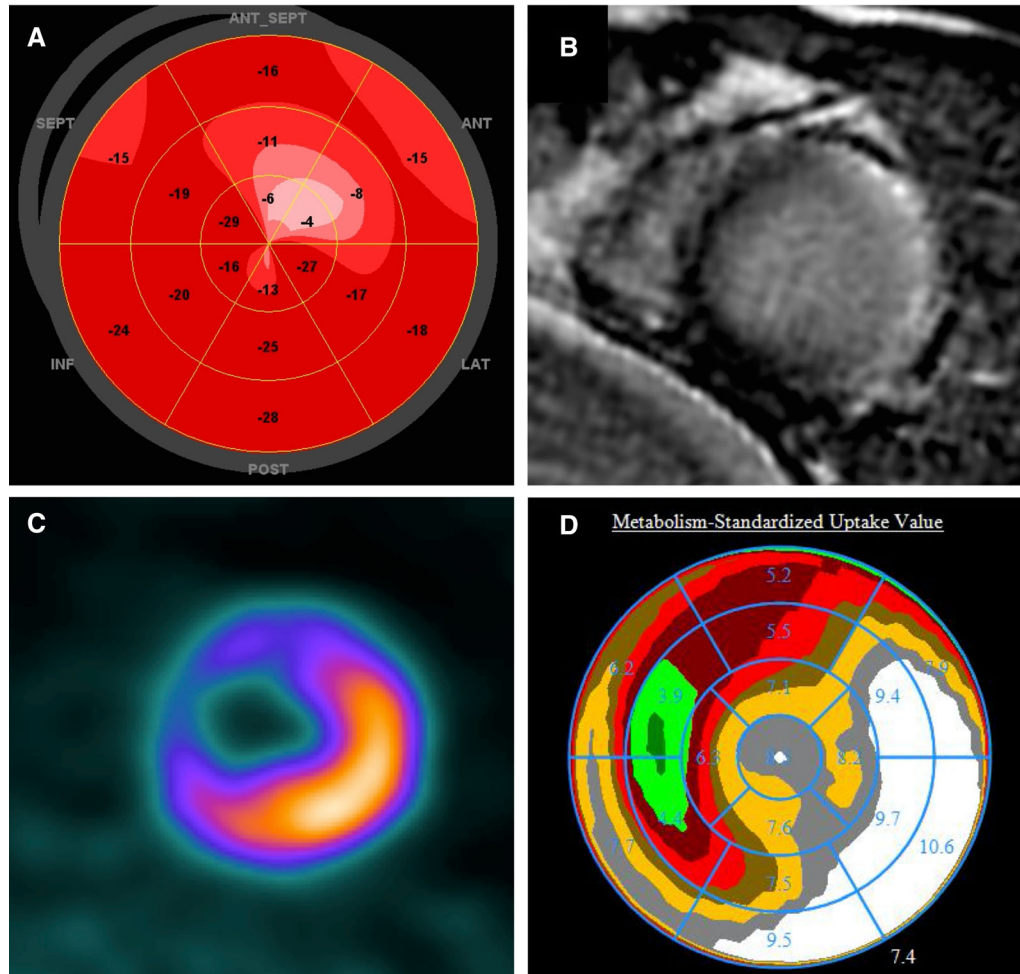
Speckle-tracking echocardiography, cardiac magnetic resonance, and ^{18}F -FDG PET in a patient with AFD. (A) Bull's-eye rendering of left ventricular global longitudinal strain (-23%). (B) Late-gadolinium enhancement (LGE) in the lateral left ventricular wall. (C) Corresponding PET showing focal tracer uptake matching the area of LGE. (D) Polar map of ^{18}F -FDG standardized uptake value (coefficient of variation 0.38).
